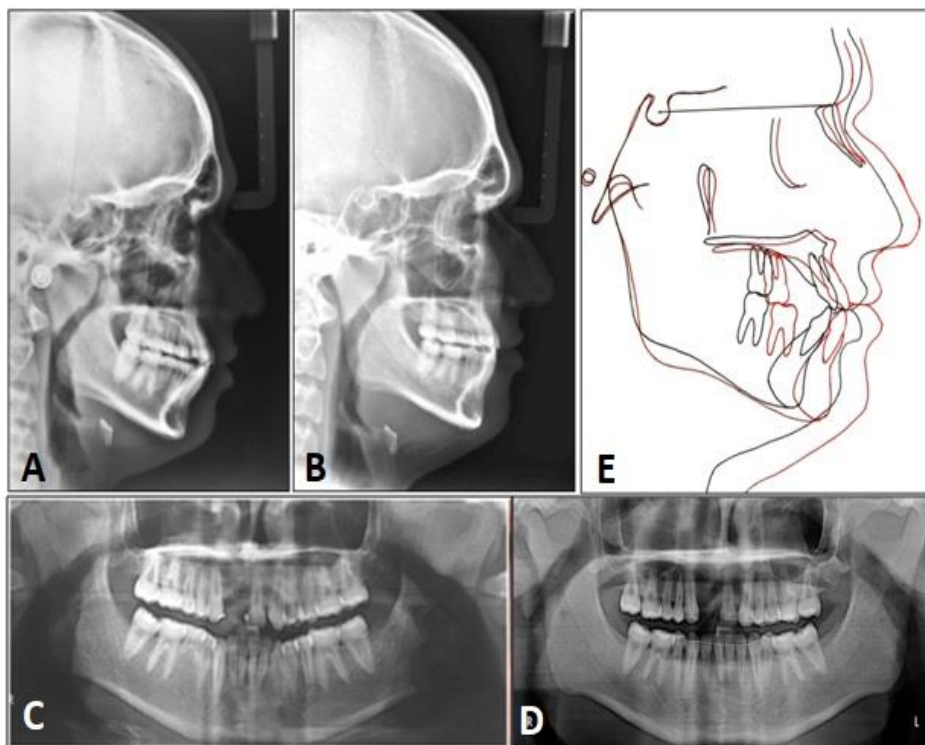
Radiographs and cephalometric superimposition. (A) Pre-treatment lateral cephalogram; (B) Post-treatment lateral cephalogram; (C) Pre-treatment orthopantomogram; (D) Post-treatment orthopantomogram; (E) Cephalometric superimposition showing the skeletal and dento-alveolar changes.
